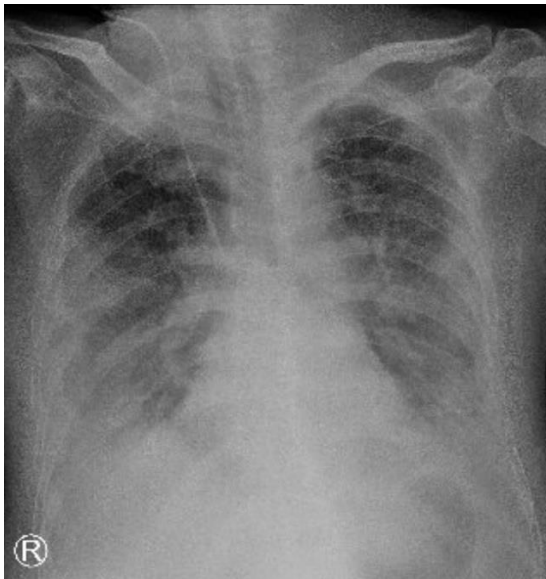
Chest X-Ray (17th Day)
